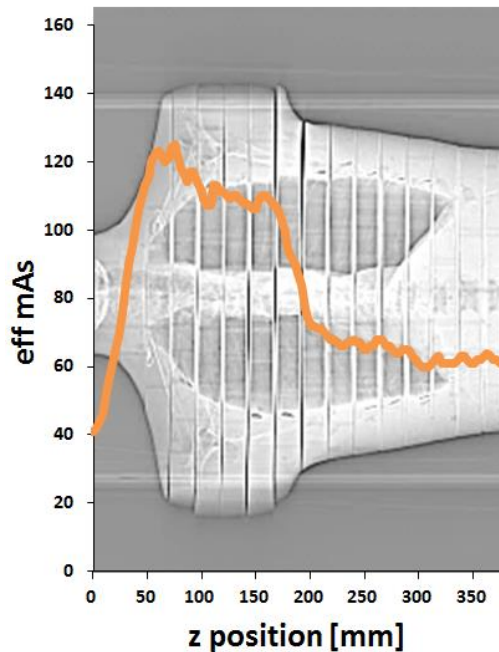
Modulation of the X-ray tube current along the length of the patient is an effective dose reducing method. The highest mAs_{eff} values are selected in the shoulder region. However, less attenuation occurs in the neck and the lower thorax. Therefore, the tube current can be reduced in these parts of the patient [4].
